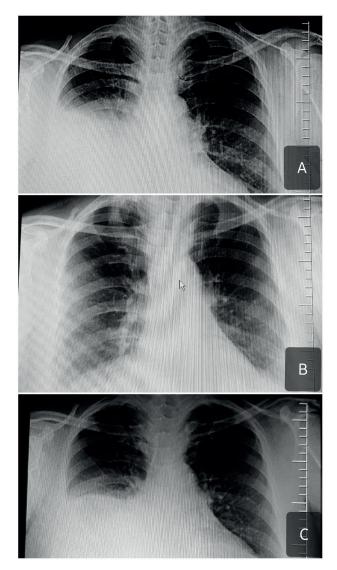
Chest X-rays: (A) The initial X-ray showing right-sided hydrothorax. (B) Repeat chest X-ray showing resolution of hydrothorax after interrupting PD. (C) Later X-ray showing recurrence of the hydrothorax after reinstituting PD.
